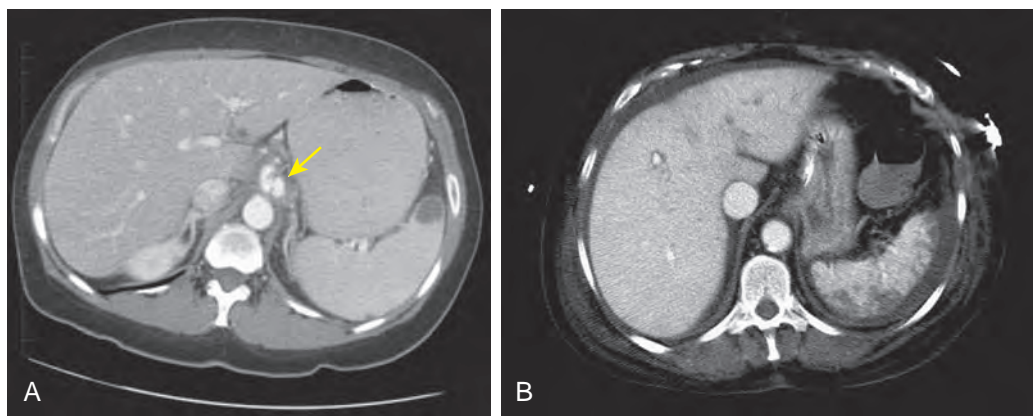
Acute splenic infarct. A. Contrast-enhanced CT demonstrates a round infarct in a patient with a mycotic aneurysm of the celiac axis (arrow). Many similar lesions throughout the spleen were seen (not shown). B. Contrast-enhanced CT in a different patient demonstrates a mottled appearance of the splenic infarcts with associated perisplenic fluid.
